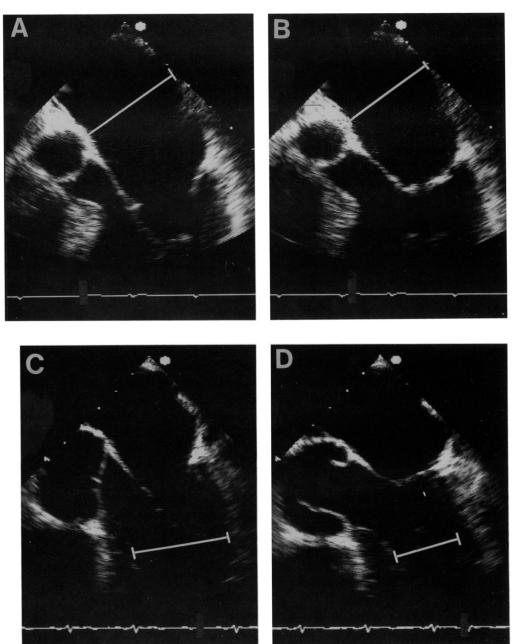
Left atrial and left ventricular fractional shortening were derived from transesophageal two-dimensional echocardiographic images in the four-chamber view using measurements (see bars) of transverse atrial diameters at atrial end-diastole (A) and atrial end-systole (B) and transverse ventricular diameters at end-diastole (C) and end-systole (D).
